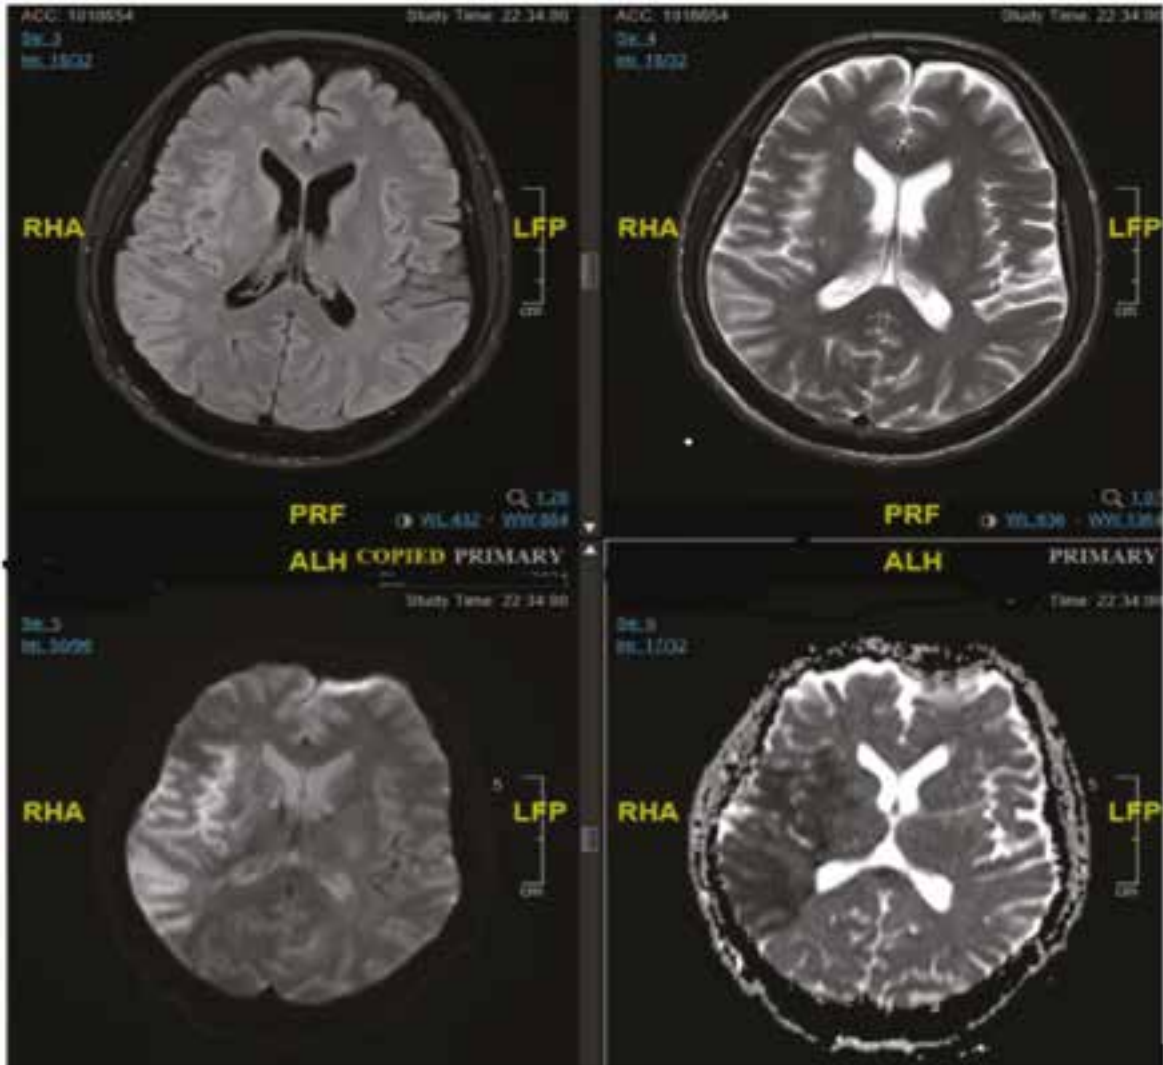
MRI FLAIR diffusion mismatch in a 55-year-old male with left sided weakness. MRI DWI showed evidence of diffusion restriction within the large diffusion restriction on DWI/ADC sequences with no clear-cut t2/flair high signal intensity in corresponding region.
